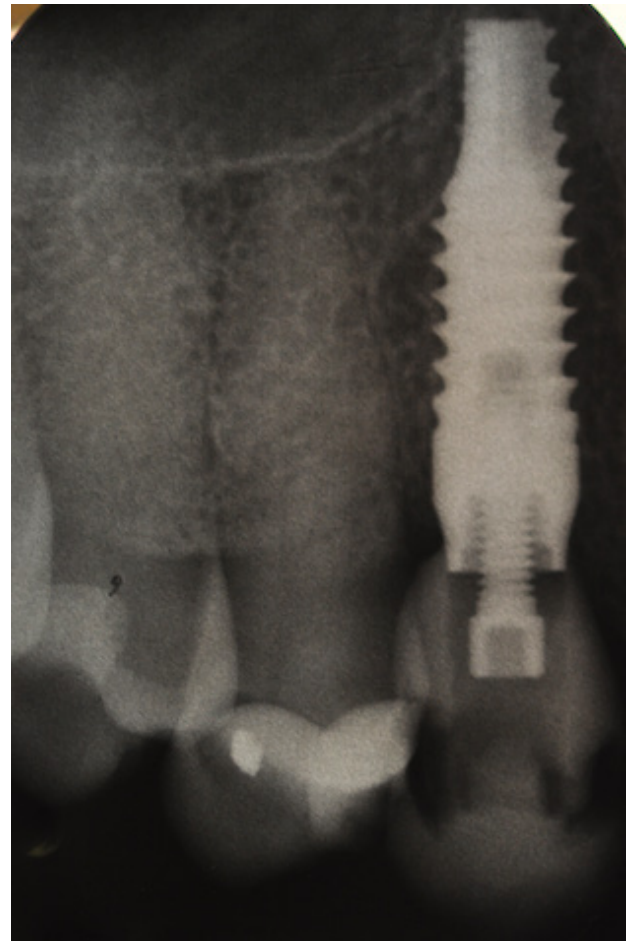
Radiographic control after 12 weeks, before placing the screwed final crown in metal-ceramic.
